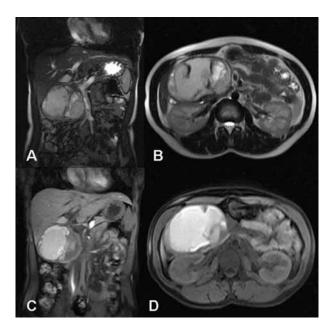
MRI was performed to verify the giant solid-cystic mass with coronal (A) and axial (B) T2- and coronal (C) and axial (D)T1- weighted images in the right of pancreatic head.
